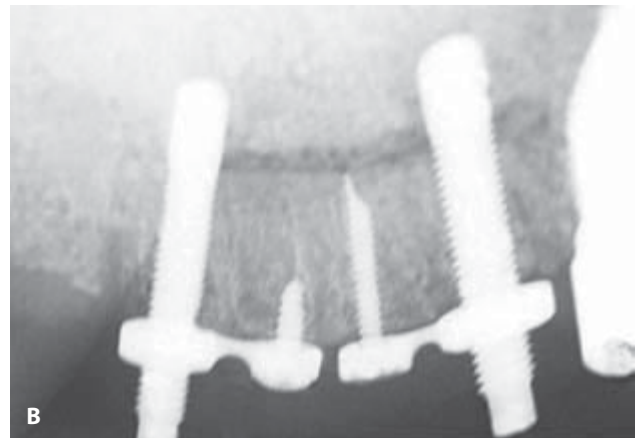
Distractor in place radiographically.
